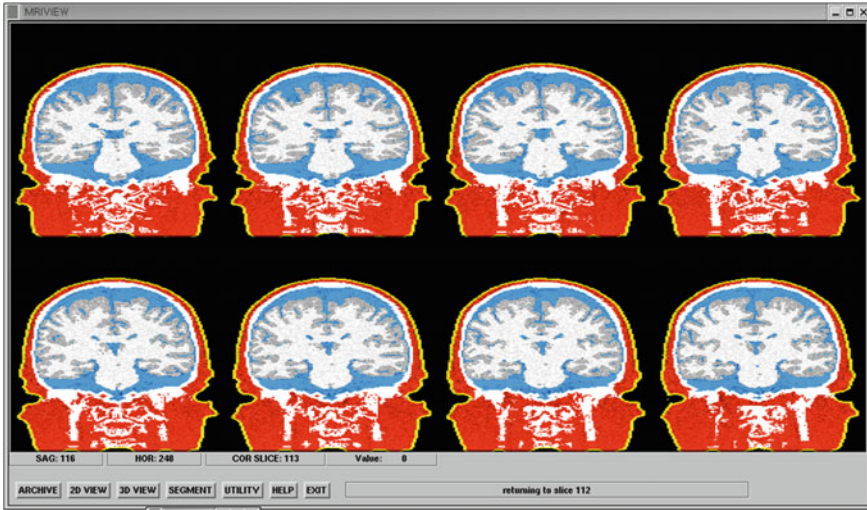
The MRVIEW 2D interface, shown here after performing a segmentation of MRI head data into 6 tissue types
